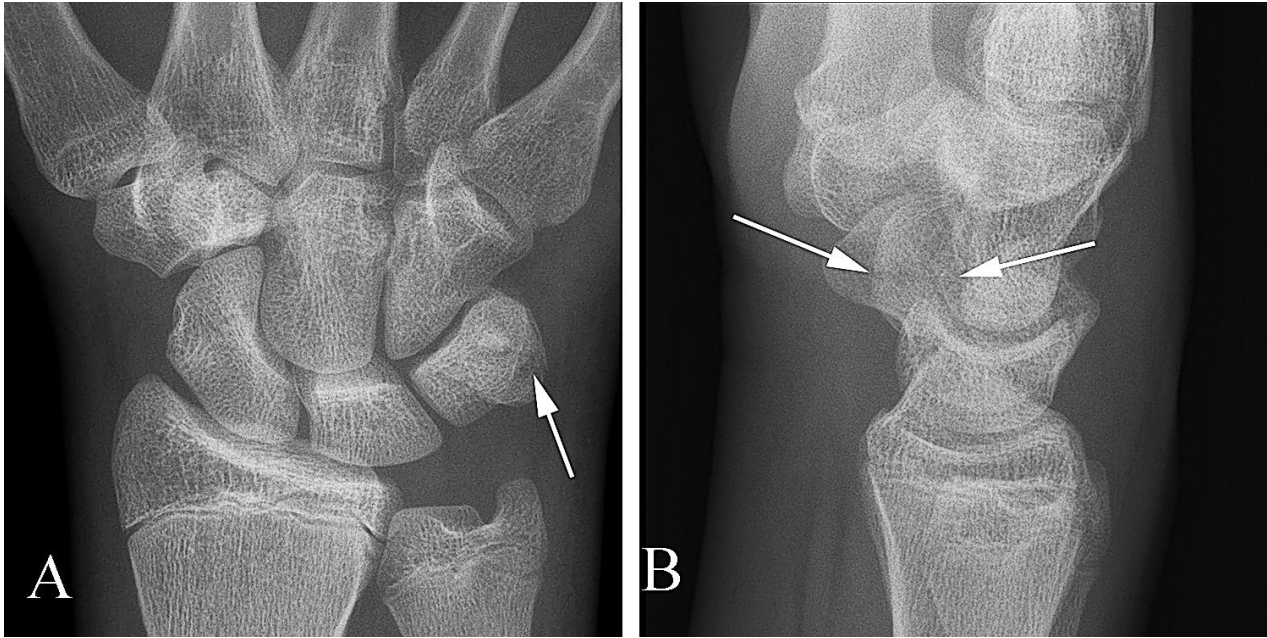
Pisiform fracture in an 18 year old man with pain following a fall on an outstretched arm. A. AP view of the wrist demonstrates a subtle lucency (arrow) through the pisiform bone. B. Lateral plain film examination confirms a fracture extending through the pisiform (arrows).
